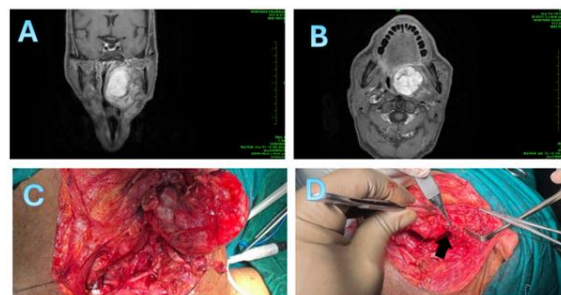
(A) Coronal MRI showing tumor extent. (B) Axial MRI showing origin from deep lobe of parotid. (C) Tumor reflected out of parapharyngeal space and lateral to mandible. (D) Preserved lower branches of facial nerve.
